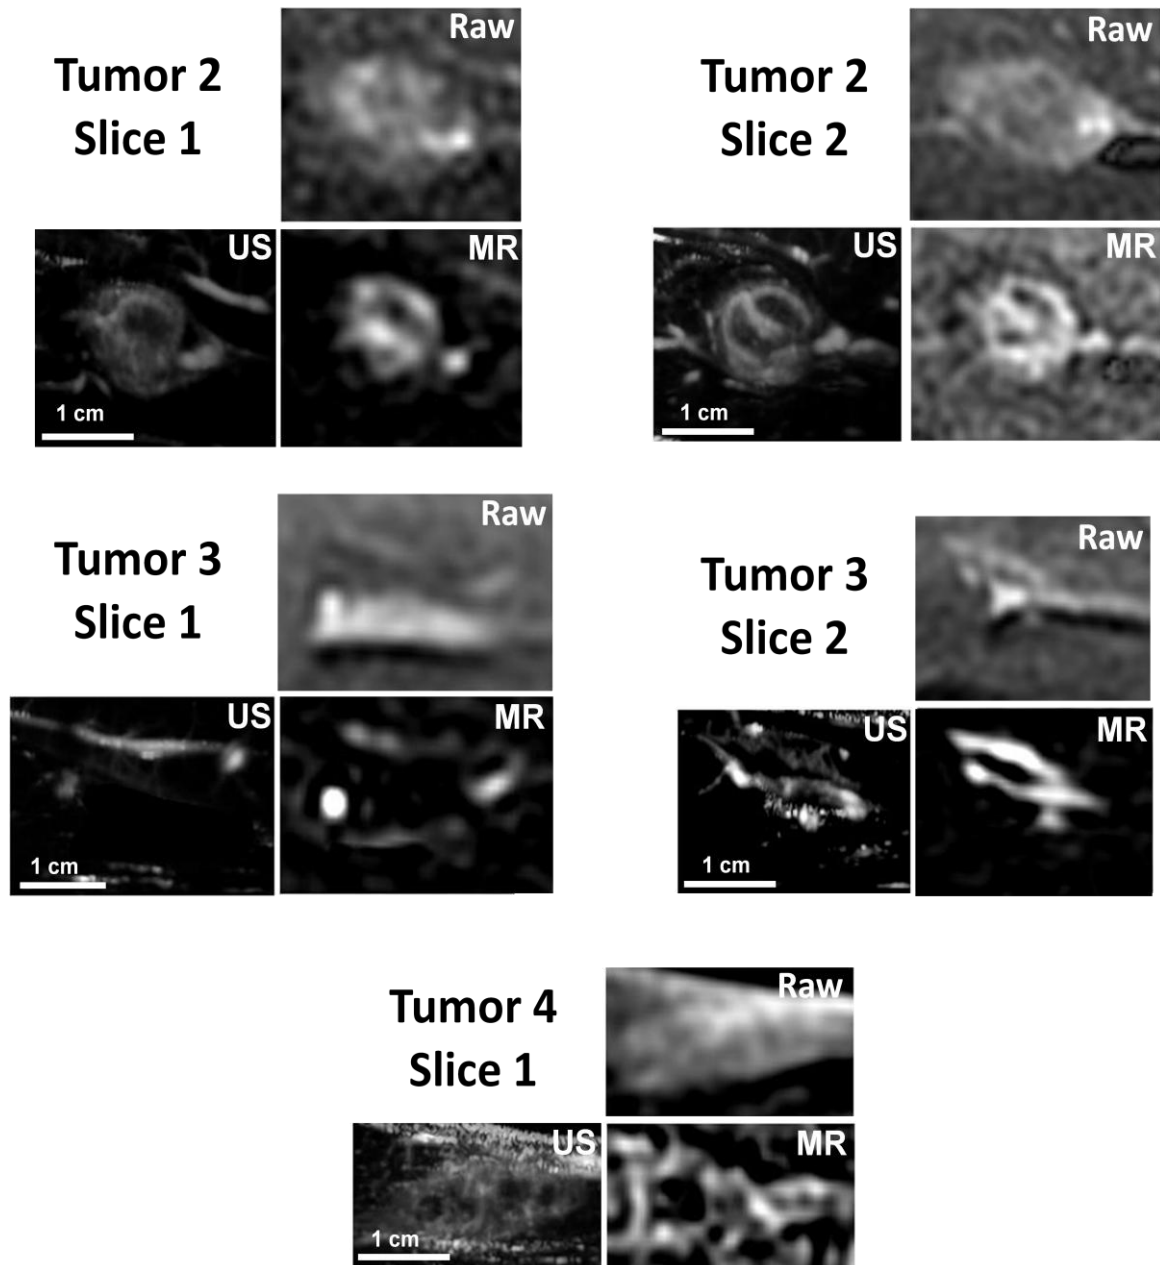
Results of applying the proposed separation method to 5 other DCE-MRI datasets. For each dataset a sample frame of the raw data (Raw) and the intravascular component image (MR) that was identified and separated using Mag-ICA algorithm are shown. In addition, the corresponding ultrasound image (US) of each dataset that shows the intravascular components of the tissue (the US data is averaged over time to reduce noise and clearly show the regions that enhance) is shown. The method was applied to the 8 available tumor datasets. In 7 out of 8 datasets the method succeeded in identifying and separating the intravascular space from the dataset. Results for 5 datasets (other than the two datasets that were shown in Figure 3-6) are shown in this figure. The intravascular MR images are thresholded by removing the pixels that enhanced less than 50% of the maximum intensity value to better visualize the enhancing areas. This figure shows the reproducibility of the algorithm in calculating the VIF *in vivo*. In the dataset that the method failed to calculate VIF the imaging parameters were modified to achieve higher temporal resolution which resulted in poor image quality (low SNR).
